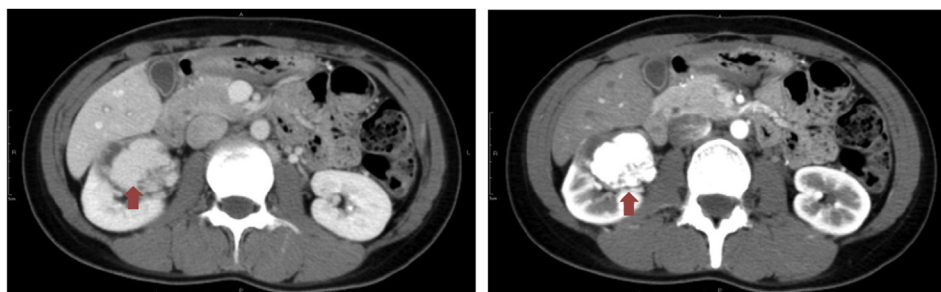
Computed tomography of the abdomen showing a tumor measuring approximately 5 cm × 4.5 cm (arrow), which raised suspicion of an arteriovenous malformation in the right kidney with a thrombus measuring approximately 1.3 cm within the right renal vein.
